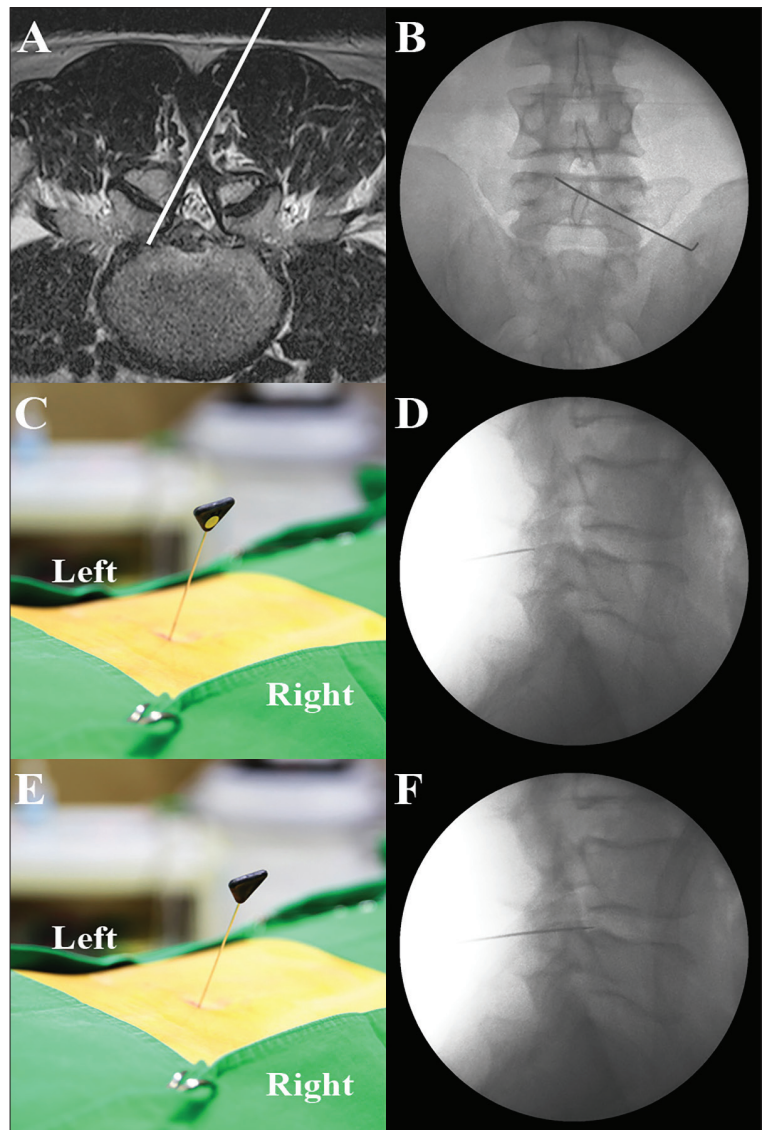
A: MRI image of patient. The white line indicates pathway of the curved round needle for the treatment of left L4-L5 lumbar disc herniation; B: AP C-arm fluoroscopic image of a patient undergoing intervention; C: The curved round needle advancing toward the point where the superior end plate and medial side of the pedicle interfaced with the concave surface facing the contralateral side; D: Lateral C-arm fluoroscopic image when the needle passed the lateral aspect of the interlaminar space and contacted the superficial border of the facet joint; E: The curved round needle was turned with the concave surface facing the ipsilateral side after contacting the superficial border of the facet joint; F: Lateral C-arm fluoroscopic image showing further advancement of the needle toward the point where the superior end plate and posterior side of the vertebral interfaced
